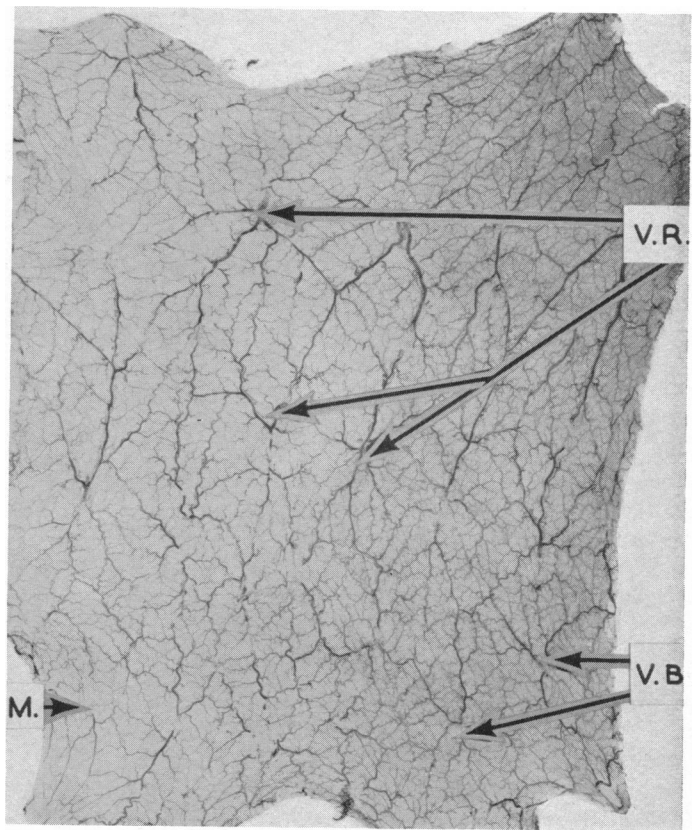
Radiograph of the mucosa of the colon which has been dissected off the muscle wall, showing the submucosal plexus. M. is the mesenteric border; V.R. indicates the division of the vasa recti, and V.B. the division of the vasa brevia.
